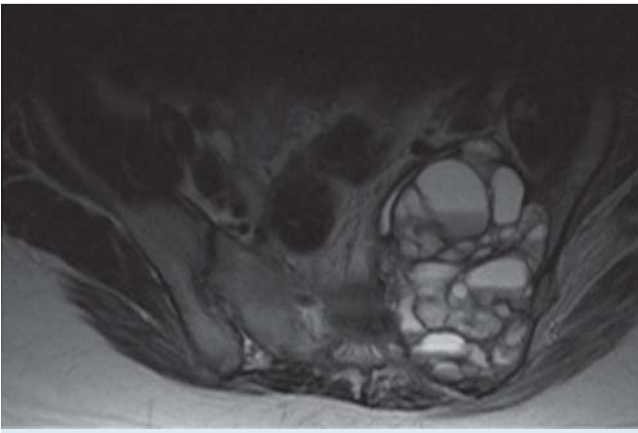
Axial MRI-scan (T1 TSE with contrast medium) of a 15 year-old girl revealing a huge ABC of the sacrum. The initial, pre-therapeutical expansion measures $8.0 \times 5.5 \times 8.3$ cm with extension to the midline. In addition a huge ventral component can be seen.
